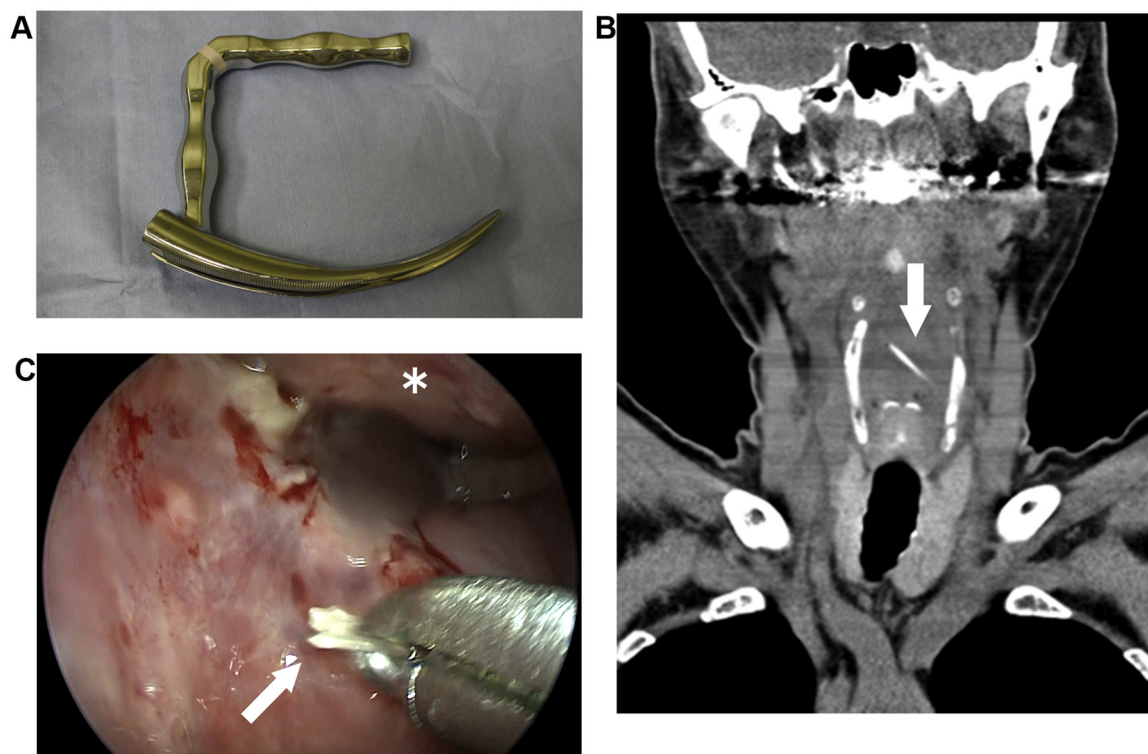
(A) Rigid curved laryngo-pharyngoscope. (B) Coronal CT shows the fish bone obliquely in the posterior wall of the hypopharynx (arrow). (C) Intraoperative view of the hypopharynx. Exposed part of the fish bone is grasped by curved forceps (arrow). White fur and erosion of the mucosa are also seen. *, post cricoid lesion.
